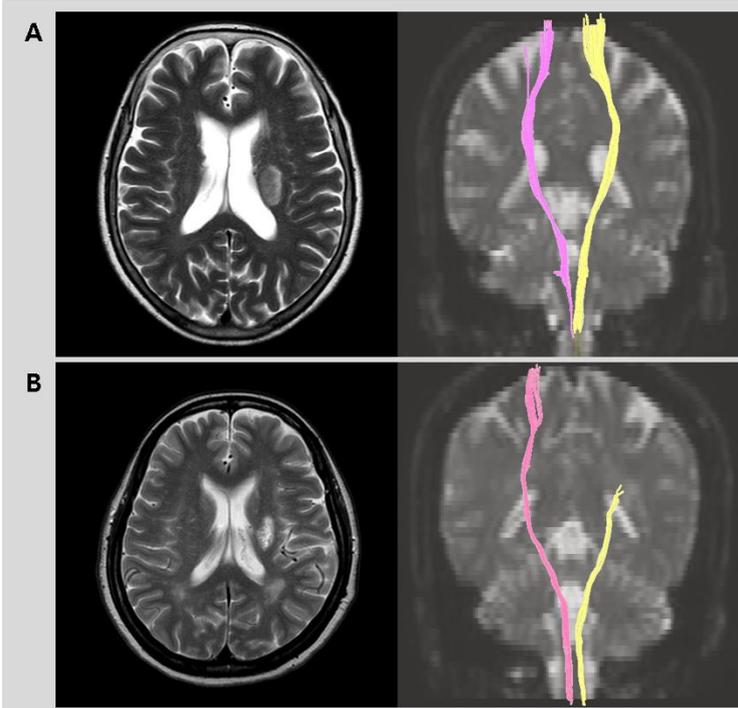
Classification according to the Results of diffusion tensor tractography (DTT) of the corticospinal tract. Axial T2-weighted magnetic resonance images (left) and coronal diffusion tensor tractography images (right). (A) DTT+: the corticospinal tract was preserved around the infarct. (B) DTT-: the corticospinal tract was interrupted by the infarct.
